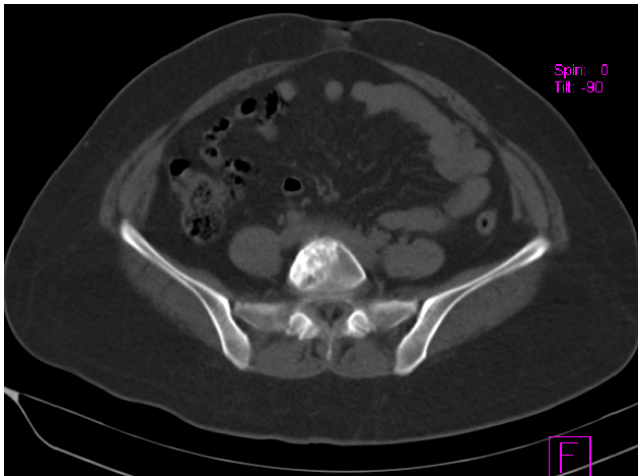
CT scan bone window shows predominantly sclerotic lesion in L5 on right side
